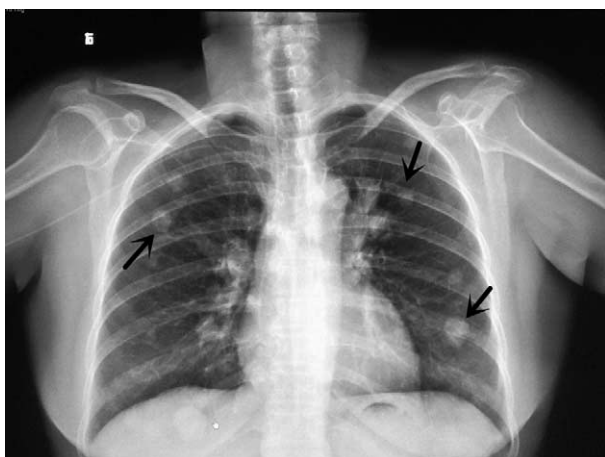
Chest radiographs revealed multiple pulmonary metastases (arrow).
